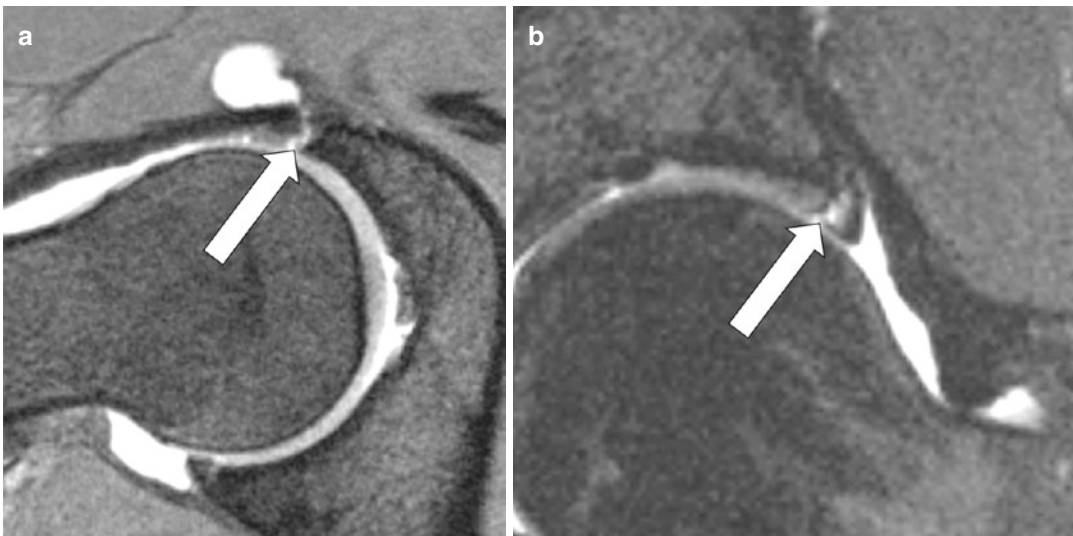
MRI arthrogram of the hip demonstrating labral tears. (a) The *white arrow* demonstrates where the labrum is torn away from the acetabulum with well-defined fluid
